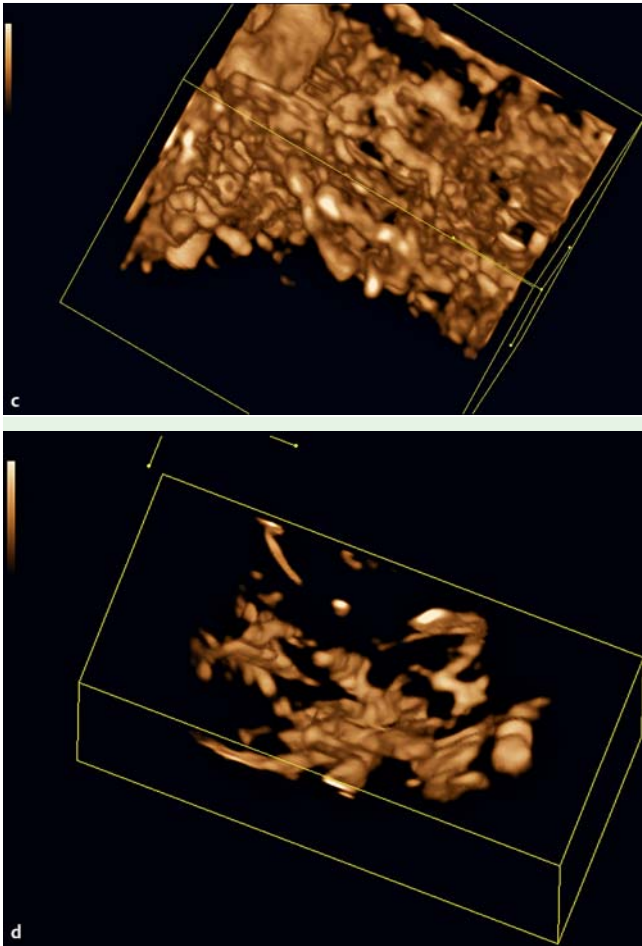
a Acquisition of a three-dimensional (3D) image in high mechanical index color Doppler mode from a patient with autoimmune pancreatitis. The rich vascularization is clearly seen, but not as impressively as in the 3D reconstruction. b Acquisition of a 3D image from a normal pancreas. Normal vascularization is shown; the large vessel below the pancreas is the splenic vein.
